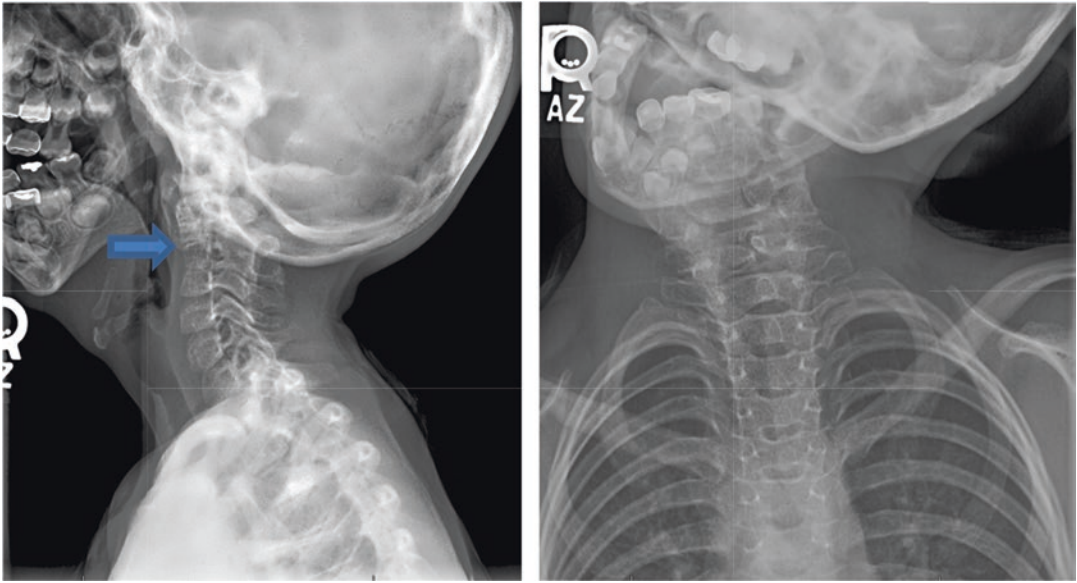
Left, right*—Lateral and AP cervical spine radiographs of a patient with Klippel-Feil syndrome, with fused C2, C3, and C4 segment (arrow) and cervical scoliosis
